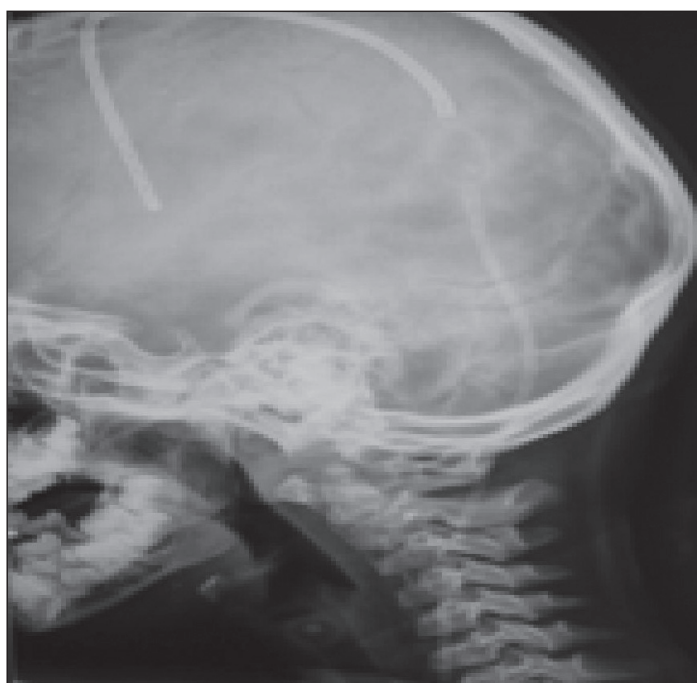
Cervical x-ray showing beginning of fusion at fractured pieces and V-P shunt materials.
